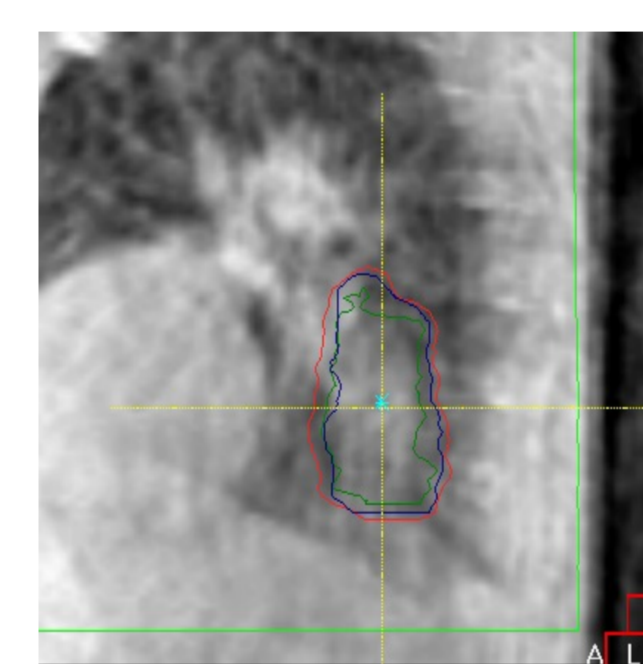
CBCT images showing changes in mGTV position
